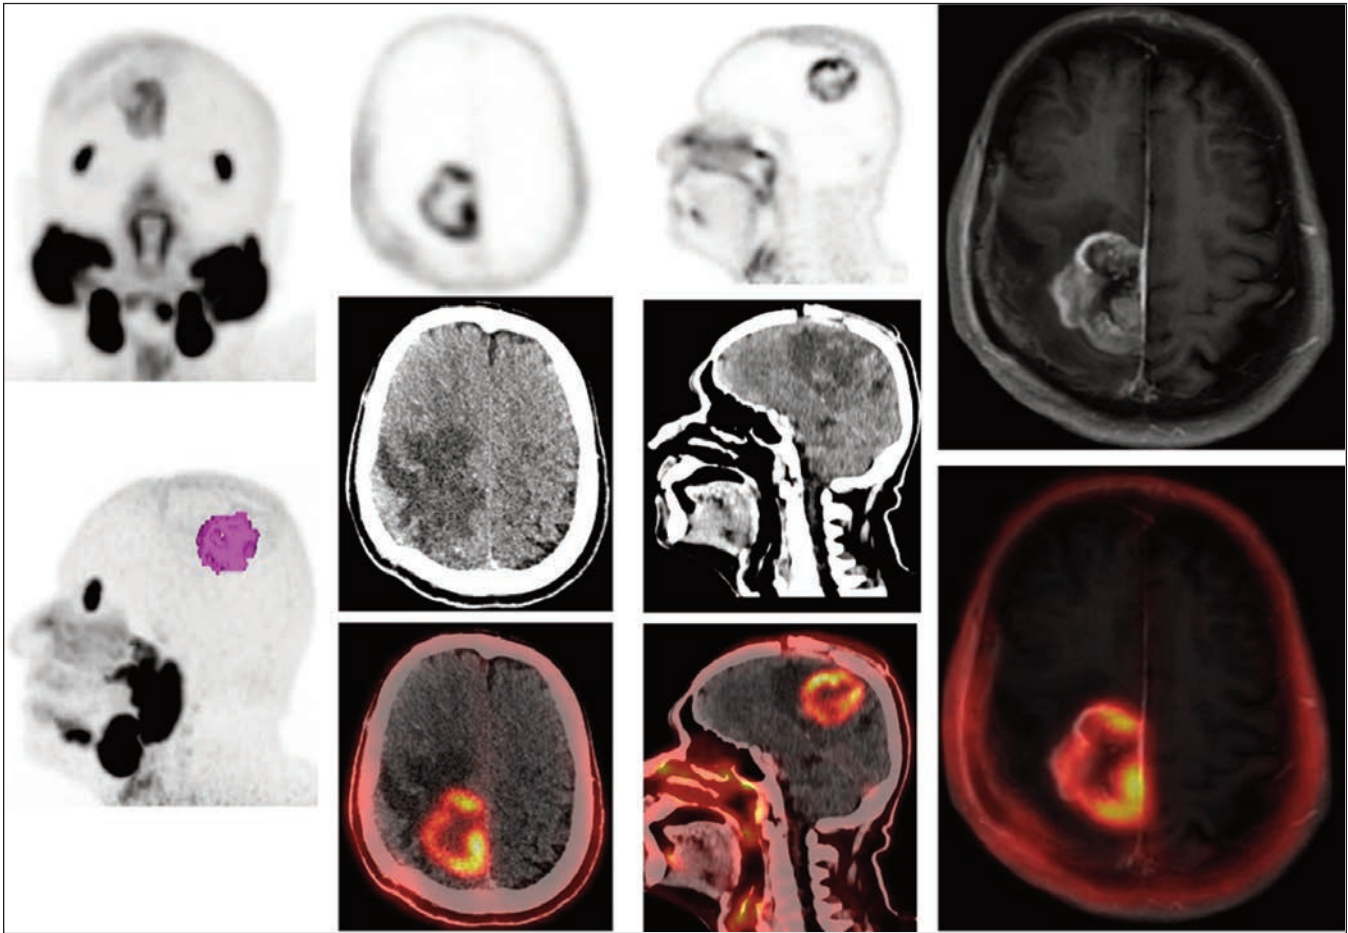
A 61-year-old male is a known case of GBM, IDH, not mutant. Post craniotomy. ^{68}Ga -PSMA shows abnormal PSMA expression lesion with SUV max 5.5 at right parietal cortex with central areas of necrosis and cystic degeneration, measuring approximately 3.4 x 4.4 x 4.0 cm along posterior and superior aspects of surgical bed. Quantitative analysis shows metabolic tumour volume (MTV)=21.7cm³. Findings are consistent with significant active residual tumour characterized by neovascularization in the tumour.
